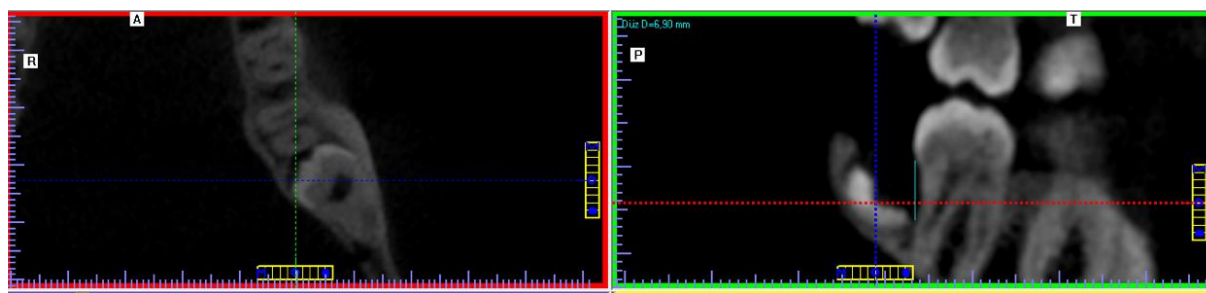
Measurement of 6.30 mm of marginal bone loss caused by tooth 38 on CBCT image (axial and sagittal sections)
